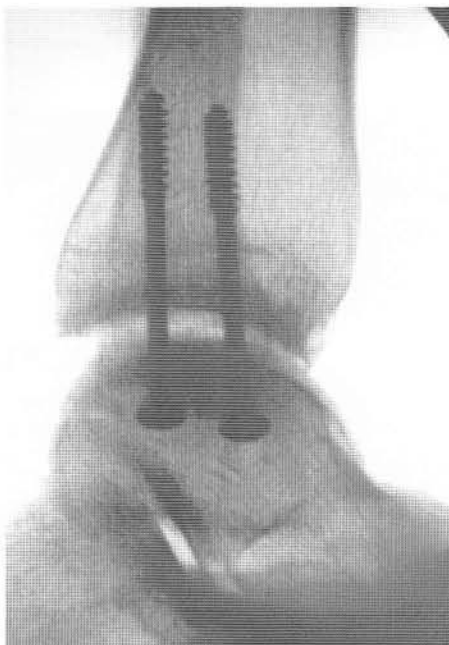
Lateral x-ray demonstrates uniform joint space.
